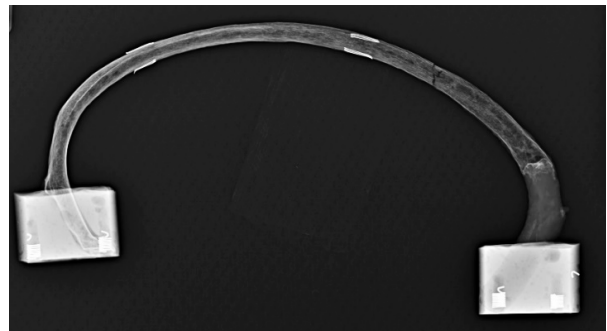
Pair 12 rib (left) and rib+CC (right) post-test x-rays (not to scale)
